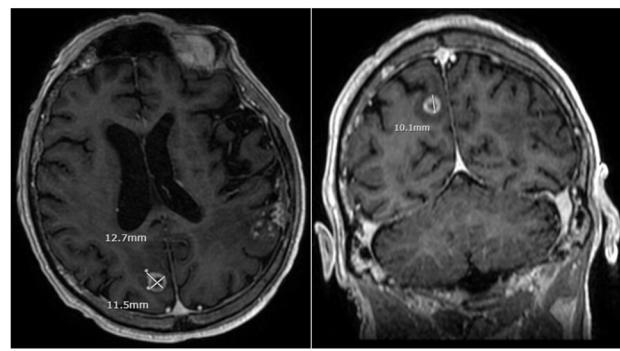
Axial and coronal T1-weighted MRI of the head with contrast showing an ovoid enhancing mass in the subcortical white matter of the right parietooccipital lobe.
